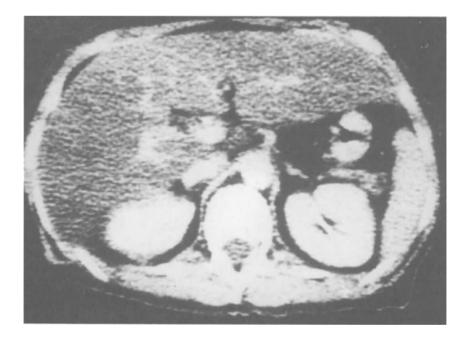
CT scan shows fatty liver. The liver is much less dense than the spleen and kidneys. In a scan unenhanced by contrast the blood vessels stand out as much more dense than the liver.
